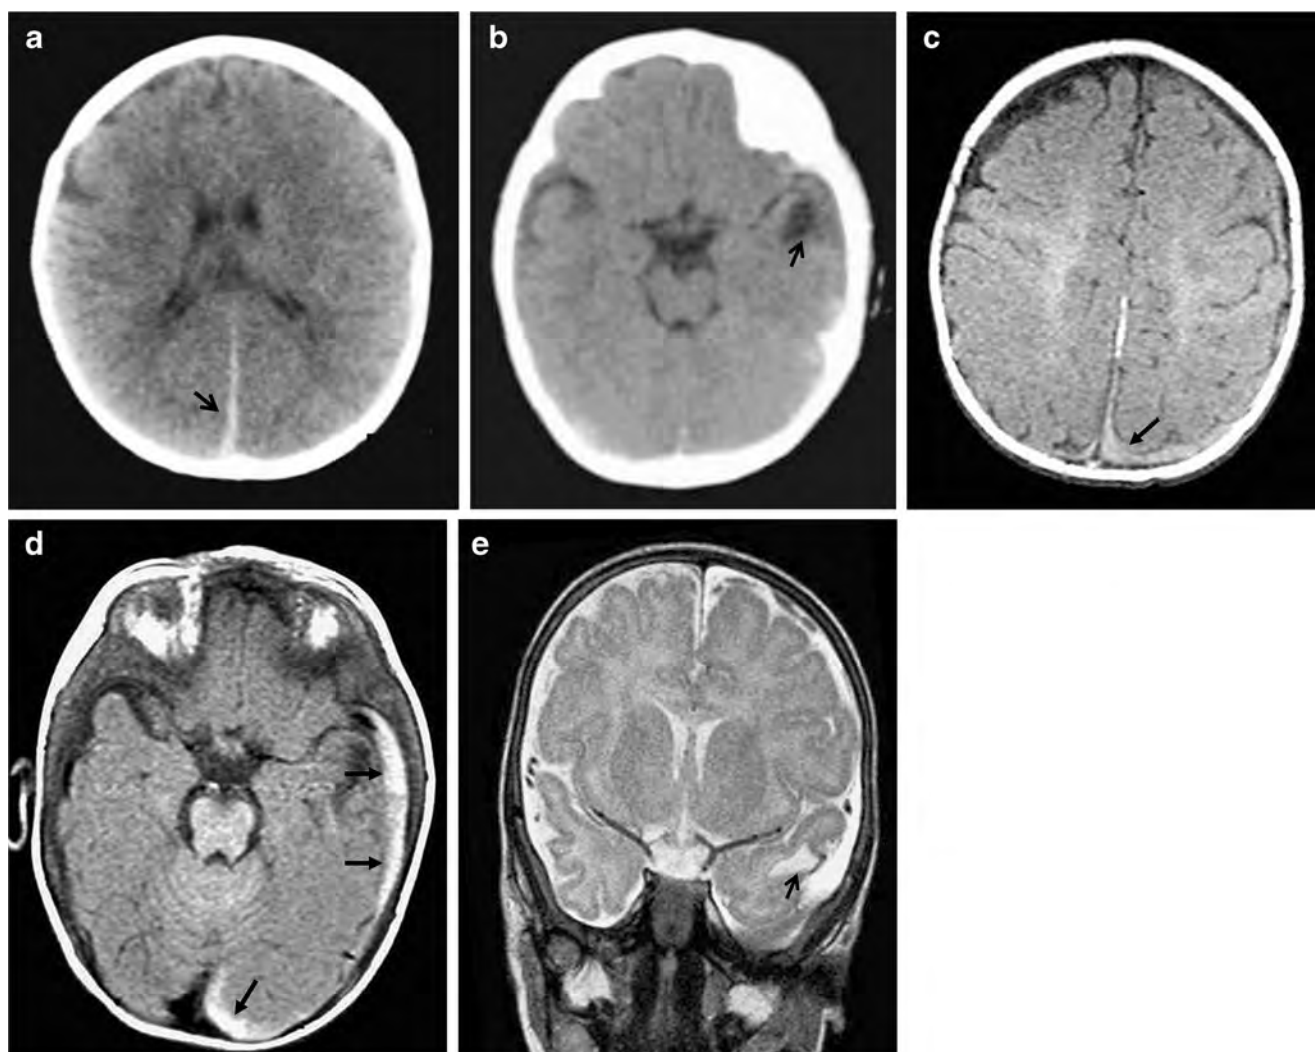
Age-different lesions in a 5-month-old boy with status epilepticus. Axial CT images showed (a) posterior parafalcine subdural hemorrhage (arrow) and (b) a left temporal old lesion (arrow). c–e MR axial T1-W image disclosed (c) the subdural interhemispheric (arrow), and (d) left
